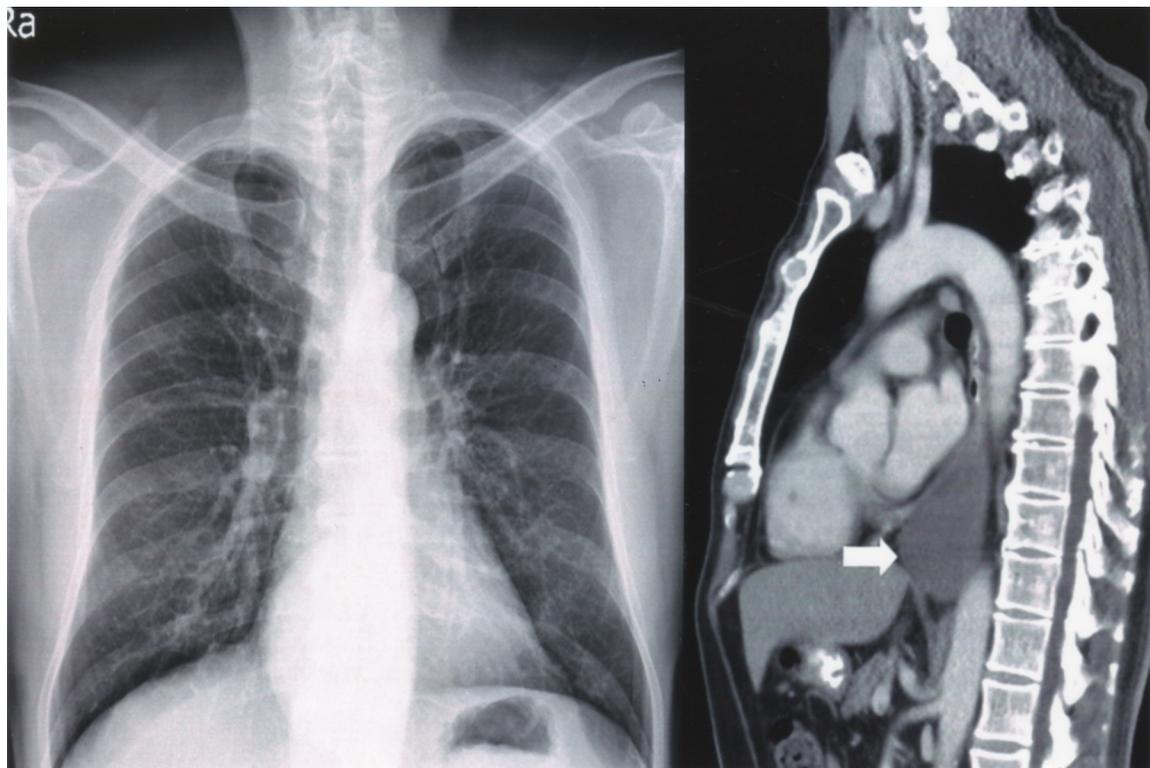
Chest images of the mediastinal myxoma. Chest X-ray reveals a well-defined soft tissue shadow superimposed at the lower mediastinal area. Computed tomography scan of the chest with intravenous contrast reveals a homogenous and non-enhanced mass lesion at the posterior mediastinum, with content density higher than water and normal fat. The lesion is indicated by the arrow.
